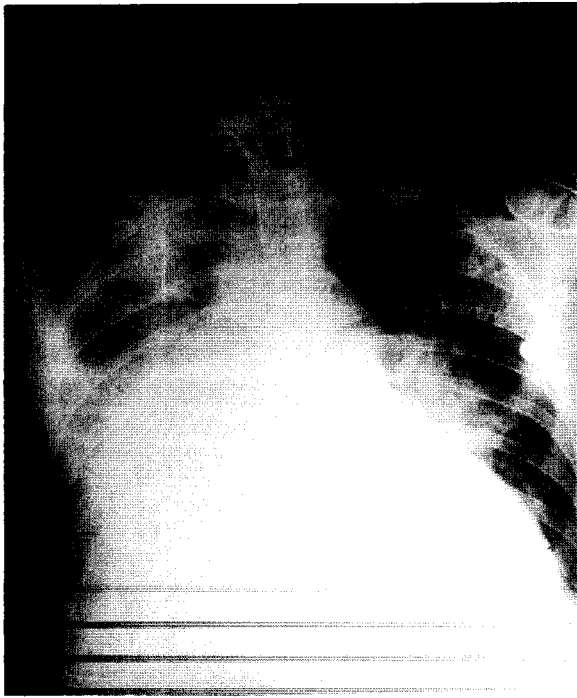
Chest roentgenogram before operation showing cardiomegaly and pulmonary congestion. The intratracheal tube for respiratory support is visible.
